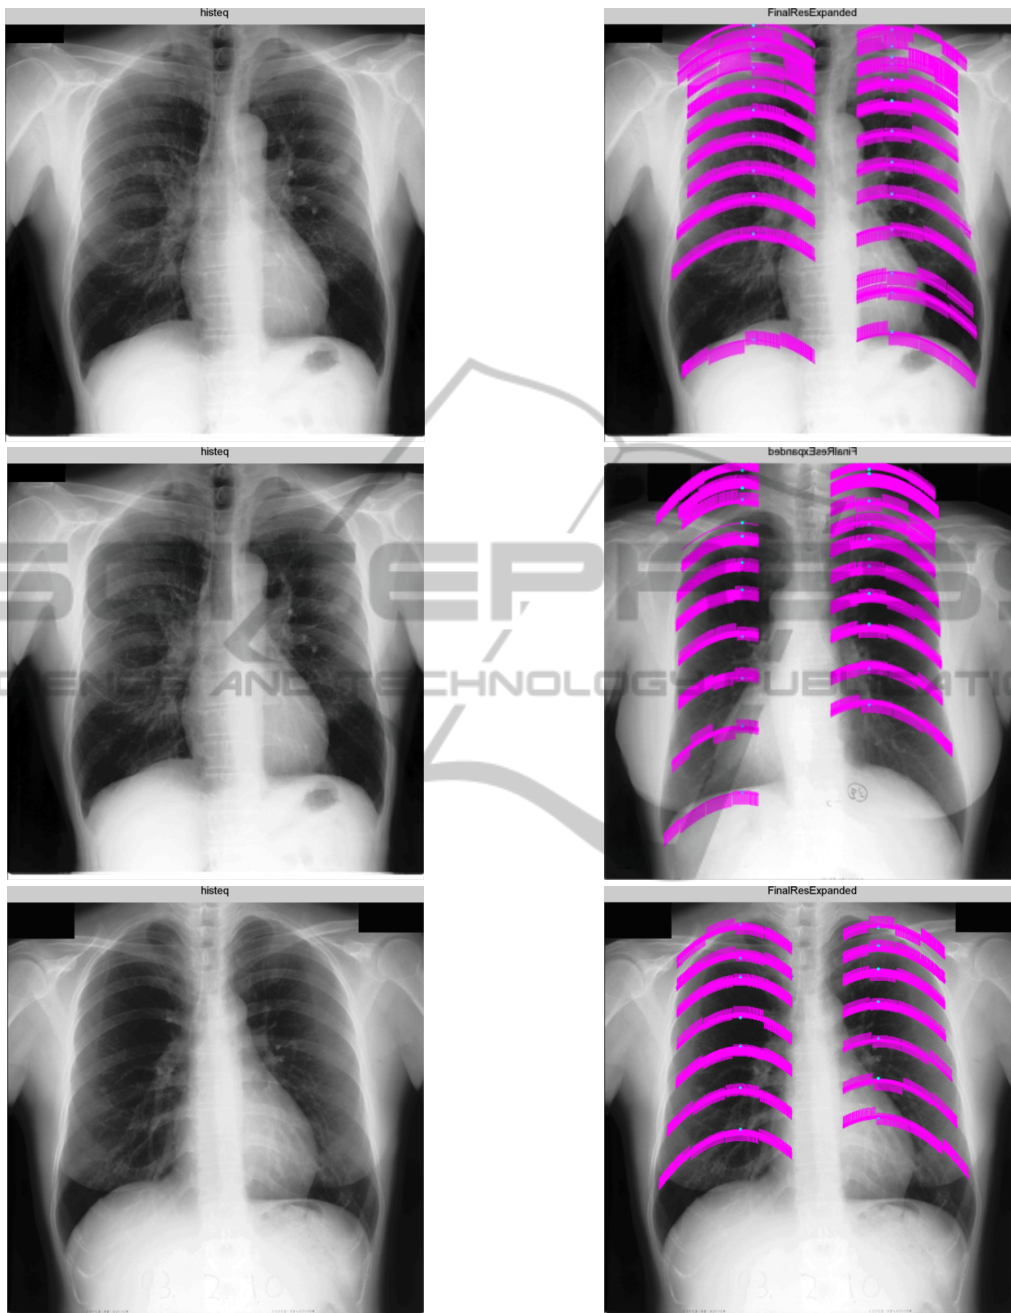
Example chest radiography images (left) and delineated ribs by our system (right).
